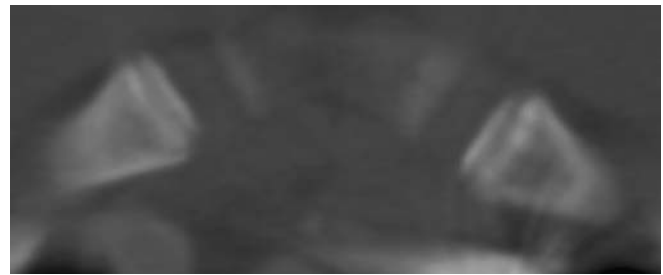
Reduced detail of a CT scan of ossification stage 2 of the medial clavicular epiphysis: ossification centre ossified, epiphyseal cartilage not ossified (male 17.3 years)
